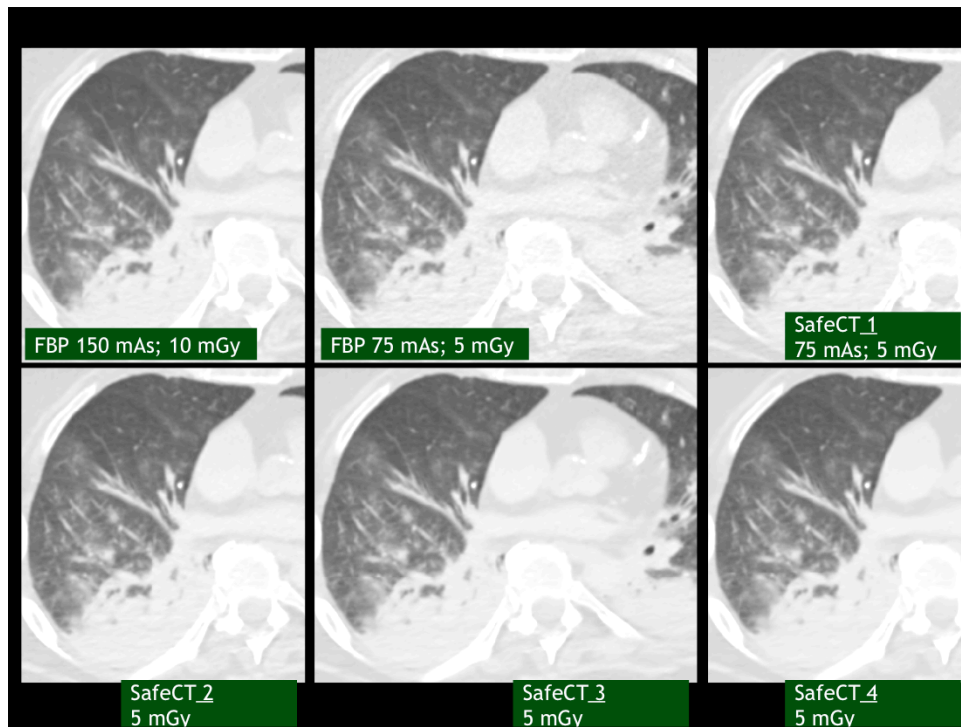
Transverse chest CT images demonstrate pneumonia and/or atelectasis in right lower lobe. L
